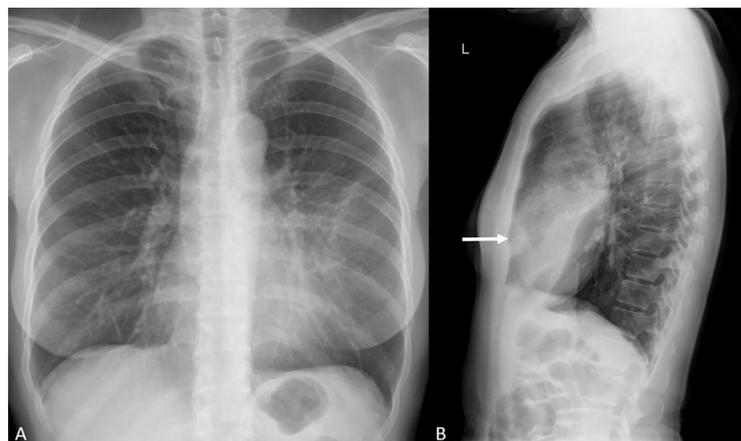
(A) Frontal and (B) lateral radiographs on the chest demonstrated focal ground-glass opacities with irregular margins in the anterior aspect of the lower left lung zone, causing a silhouette with the left side of the heart border.
